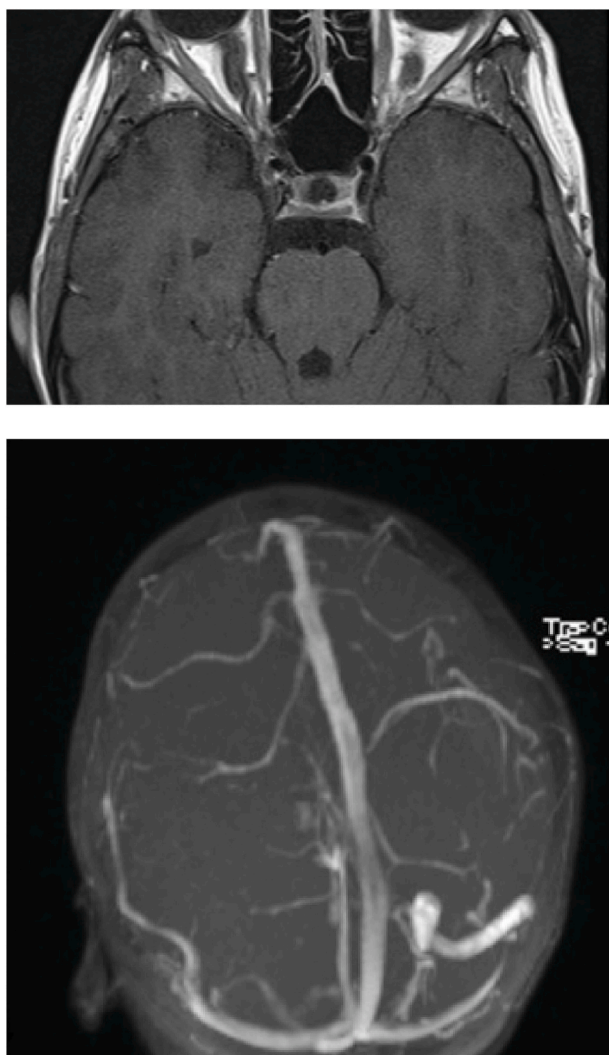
Contrast-enhanced T1-weighted magnetic resonance imaging (upper) showing a heterogeneous abnormal enhancement of left cavernous sinus and magnetic resonance venography (lower) demonstrating no perfusion of the left sigmoid sinus and jugular vein.
